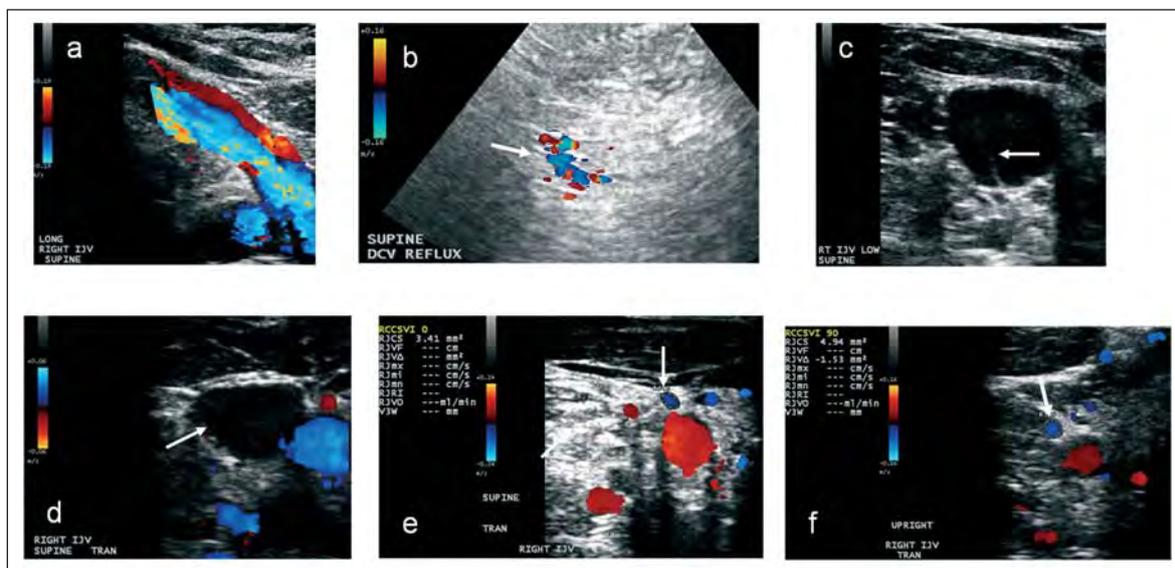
Examples of positive Doppler sonography CCSVI criteria: (a) reflux/bidirectional flow directed toward the brain for a duration of >0.88 s in the supine position in the right internal jugular vein (RIJV); (b) reflux/bidirectional flow in one of the deep cerebral veins for a duration of 0.5 s; (c) septum intraluminal structural abnormality in the right internal jugular vein causing hemodynamic flow abnormality; (d) no visible flow in the RIJV in the supine position; (e and f) reverted postural control of the RIJV with negative ΔCSA .
